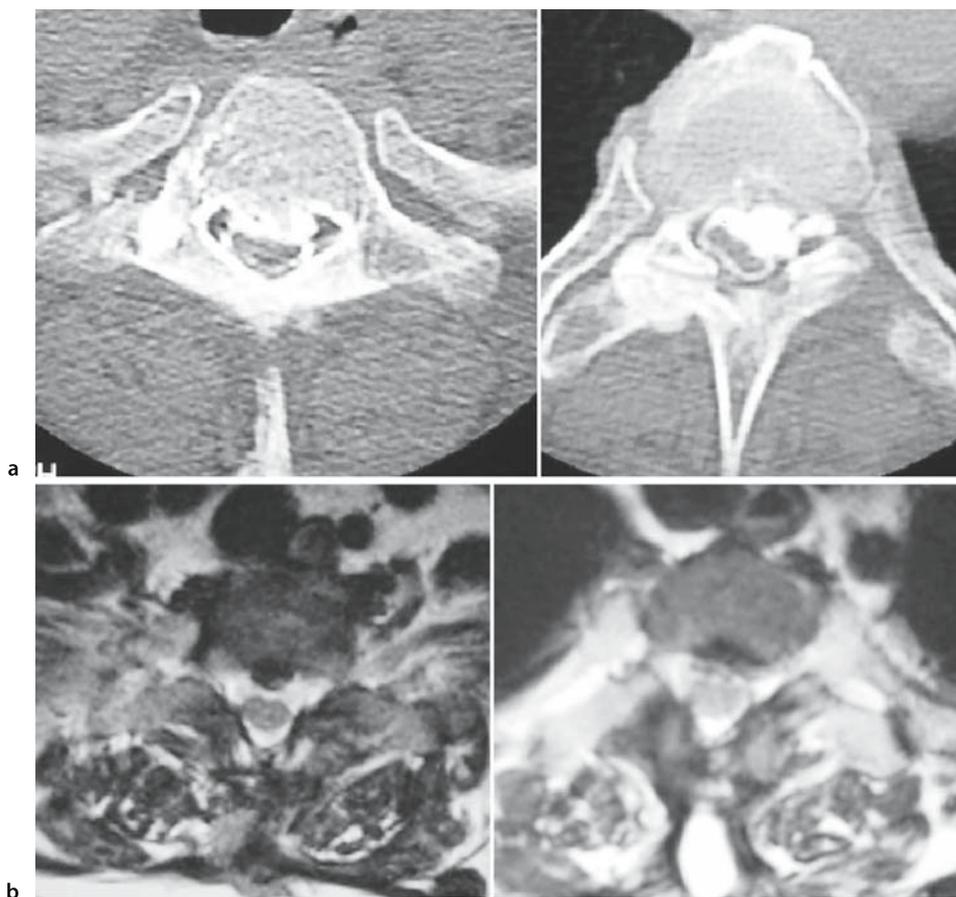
a Preoperative computed tomography (CT) scan of the upper thoracic level. Note the spinal cord compression from ossification of the posterior longitudinal ligament (OPLL).
